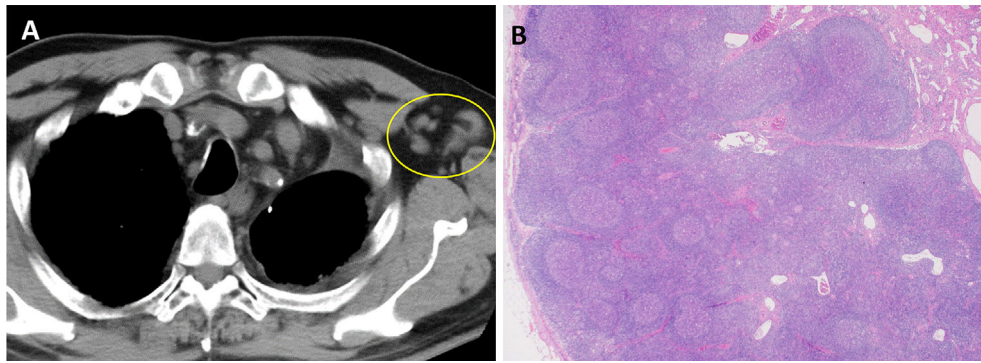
CT and pathological images of Patient 2. (A) Chest CT showed enlarged lymph nodes in the left axilla (yellow circle). (B) Pathological findings showed benign hyperplasia.
